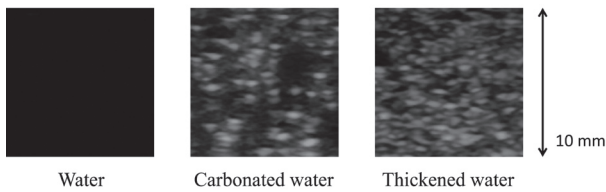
Comparison of ultrasound images of three swallowing materials: water, carbonated water, and thickened water.
